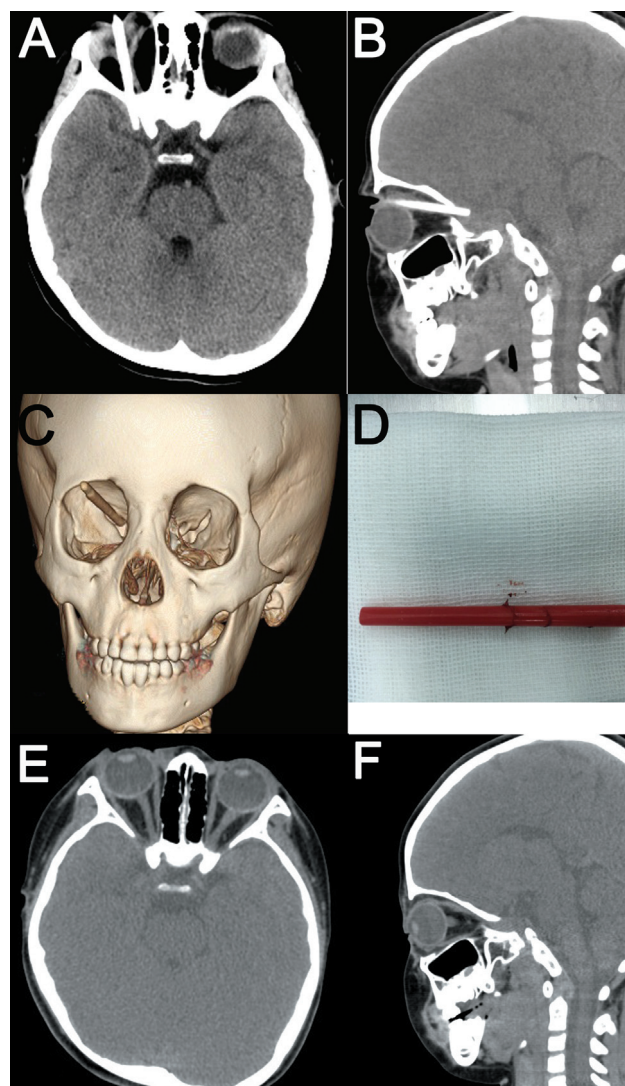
Noncontrast head computed tomography scans (A, axial image; B, sagittal image) and three-dimensional reconstruction (C) showing the chopstick passing through the right superior orbital fissure into the cranium. An intact chopstick, which measured 5.3 cm in length, was removed in one piece (D). Immediate postoperative noncontrast head computed tomography scans (E, axial image; F, sagittal image) showing no evidence of neural damage or intracranial hemorrhage.
